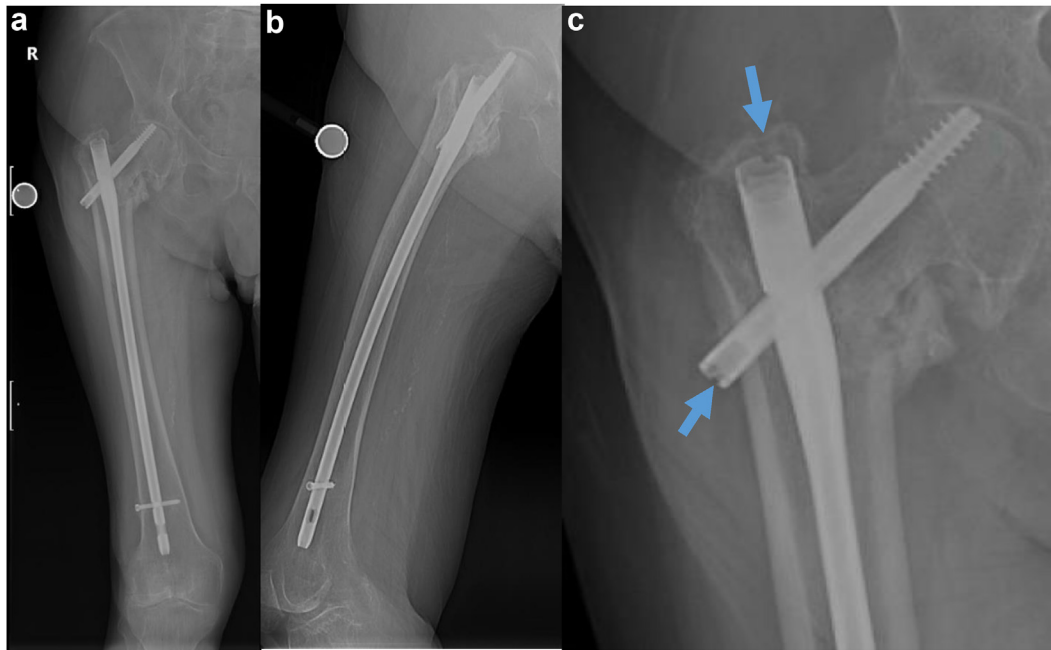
AP (a) and lateral (b) radiograph of the right femur with Gamma nail (Stryker) demonstrating device failure due to superior cut-out and varus intertrochanteric fracture nonunion. (c) Characteristics that identify this nail as Gamma (Stryker) include the dovetails present at the lateral aspect of the lag screw to allow engagement of inserter and extractor as well as a similar dovetail (arrows) present proximally in nail itself. AP, anteroposterior.
